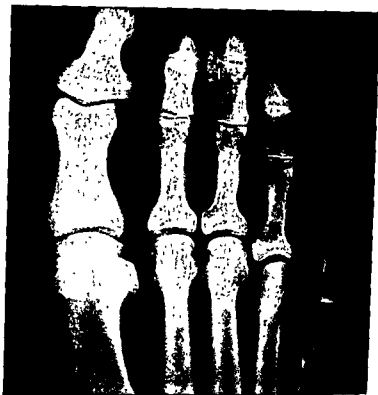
Roentgenogram of the right foot of FC, a 58 year old male who has suffered four attacks of acute gout, the first one in 1951. The last attack began 48 hours following extraction of a cataract from the left eye. The serum uric acid was 7.4 mg/100 ml. Areas of decreased density are present in the medial and central portions of the head of the first metatarsal.
